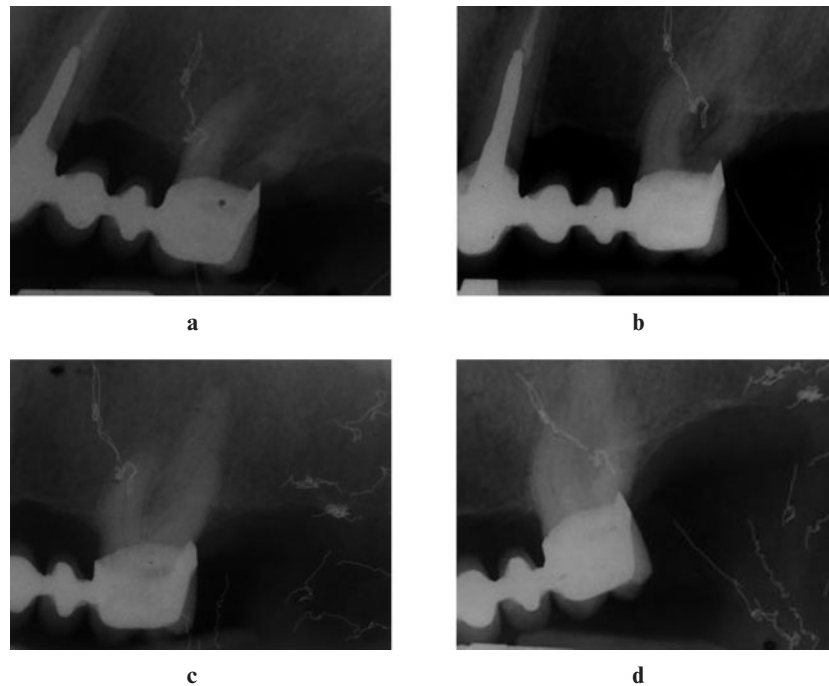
Intraoral radiographs of the maxillary left molar area in different periods. (a,b) At the age of 65 years and (c,d) at the age of 59 years
